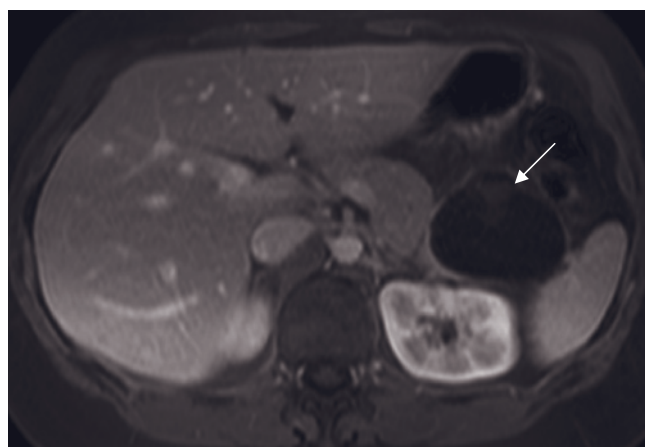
Mucinous cystadenocarcinoma. T2-weighted ETSE (a), T1-weighted SGE (b), T1-weighted fat-suppressed SGE (c), immediate postgadolinium T1-weighted SGE (d), and 90-s postgadolinium fat-suppressed SGE (e) images. There is a large cystic
